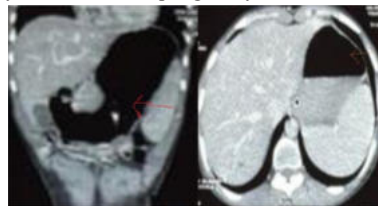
CT Scan Abdomen Showing Grossly Dilated Stomach in Different Views
